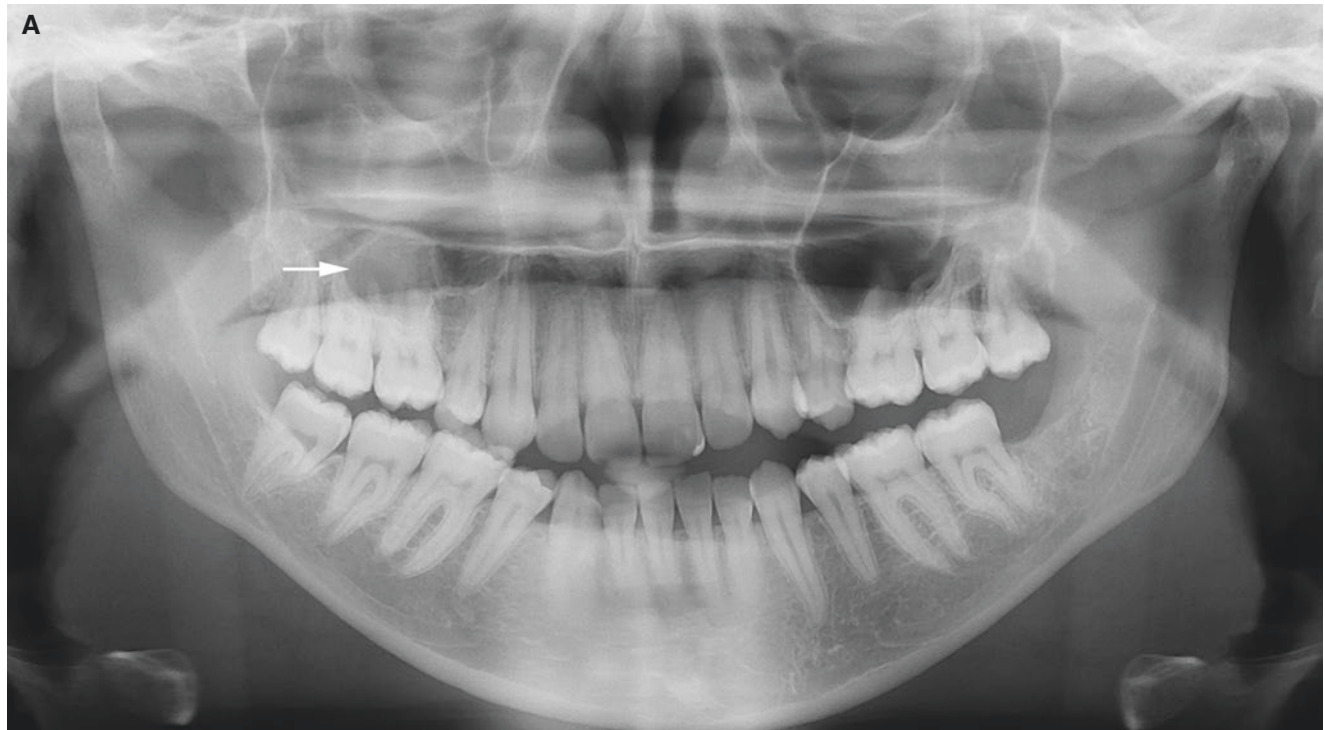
Retention cyst, maxillary sinus; 23-year-old female, incidental finding. (A) Panoramic view shows radiopacity (arrow) in the right maxillary sinus, clinically suspected to be a keratocystic odontogenic tumor due to apparently corticated outline. (B) Axial (with cursor lines for C and D), (C) coronal, (D, E) sagittal, and (F) axial (with cursor line for E) CT images show radiopacity in the right maxillary sinus without cortical outline (arrow) and without bone destruction but
